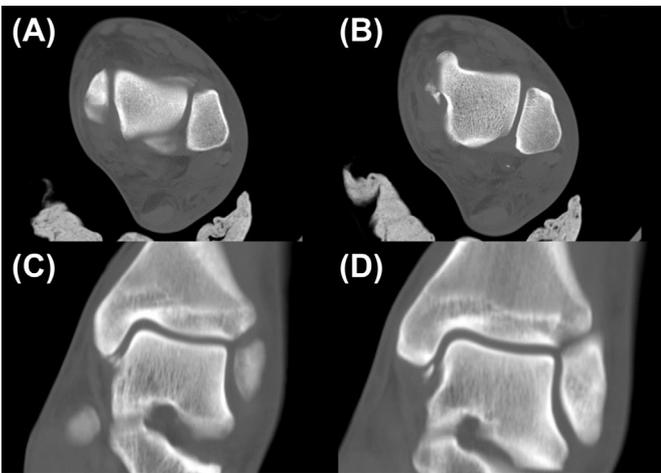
(A–D) Computed tomography confirming the fractures without obvious disruption of the syndesmosis.
